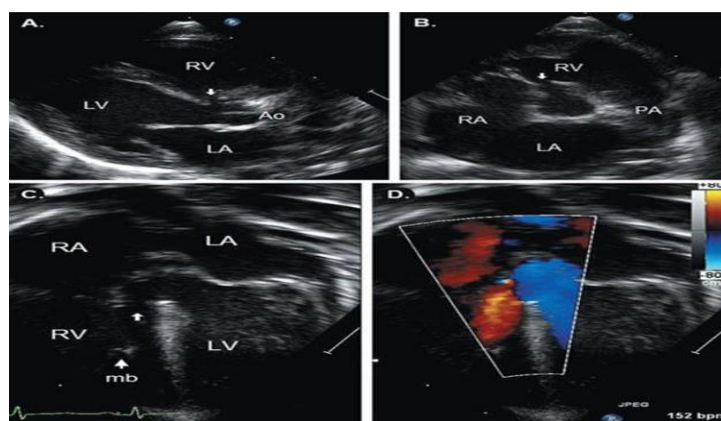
Echocardiography of VSD
